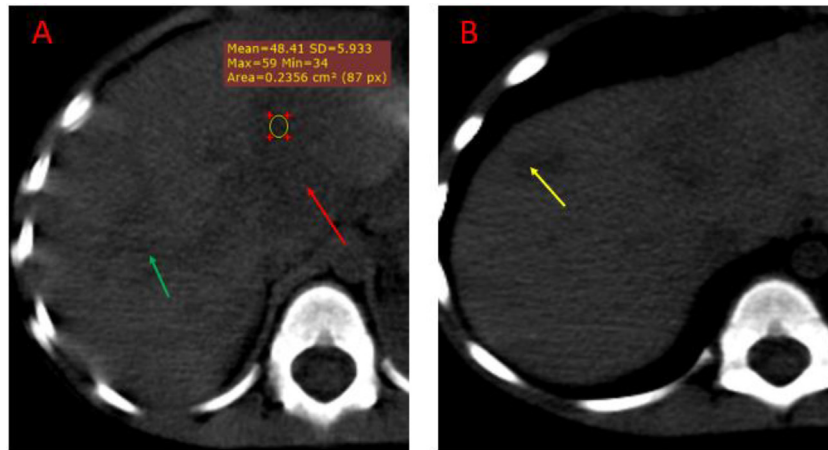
Axial noncontrast abdominal CT scan. Image A shows hypoattenuating branching type (green arrow) and hilar (red arrow) lesions. Image B shows a peripheral parenchymal lesion (yellow arrow)
